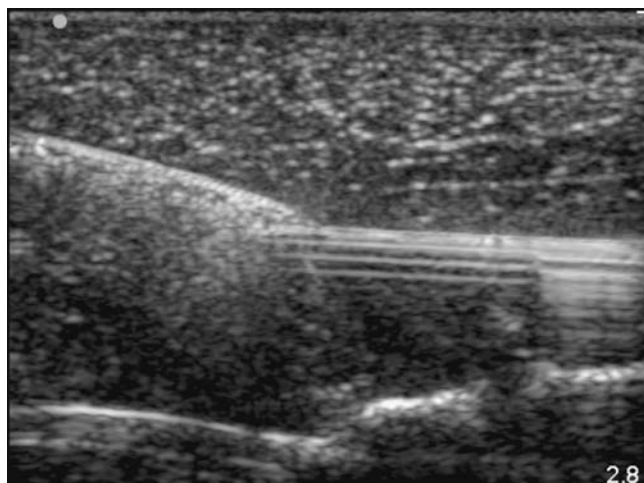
depicts the closed and open positions of the forceps and their appearance on ultrasound. The superficial aspect of the forceps will be visualized, but beam scatter will obscure the deeper portion.
